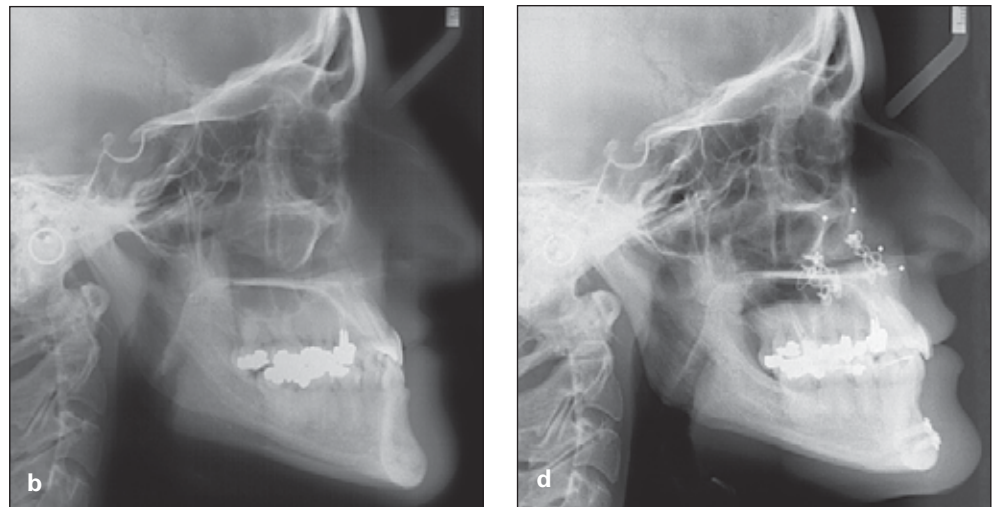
Patient 2. Preoperative (a,b) and postoperative (c,d) orthopantomographs and lateral cephalometric radiographs showing skeletal changes.
